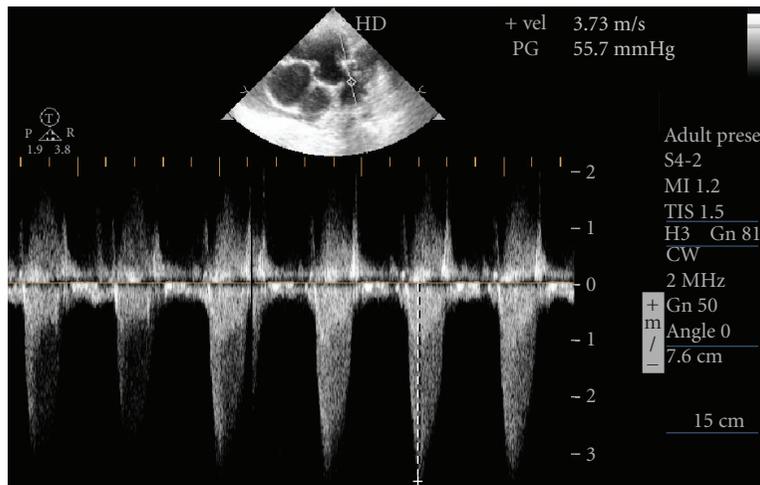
Parasternal short axis view depicting moderate grade pulmonary stenosis with gradient across the valve as 55 mmHg.
